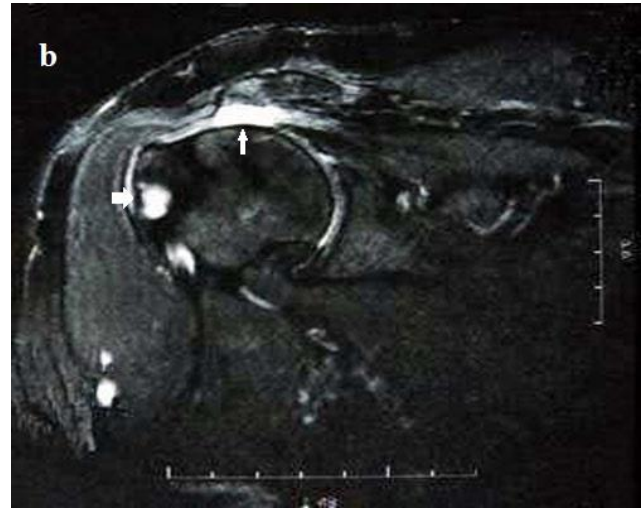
Coronal T2-weighted MRI image of the left shoulder, full thickness tear extending from the articular surface to the bursal one in supraspinatus tendon (thin white arrow), partial retraction, effusion in subacromial-subdeltoid bursa, degenerative changes in acromioclavicular joint, cystic degenerative lesions in humeral major tubercle (thick white arrow).
